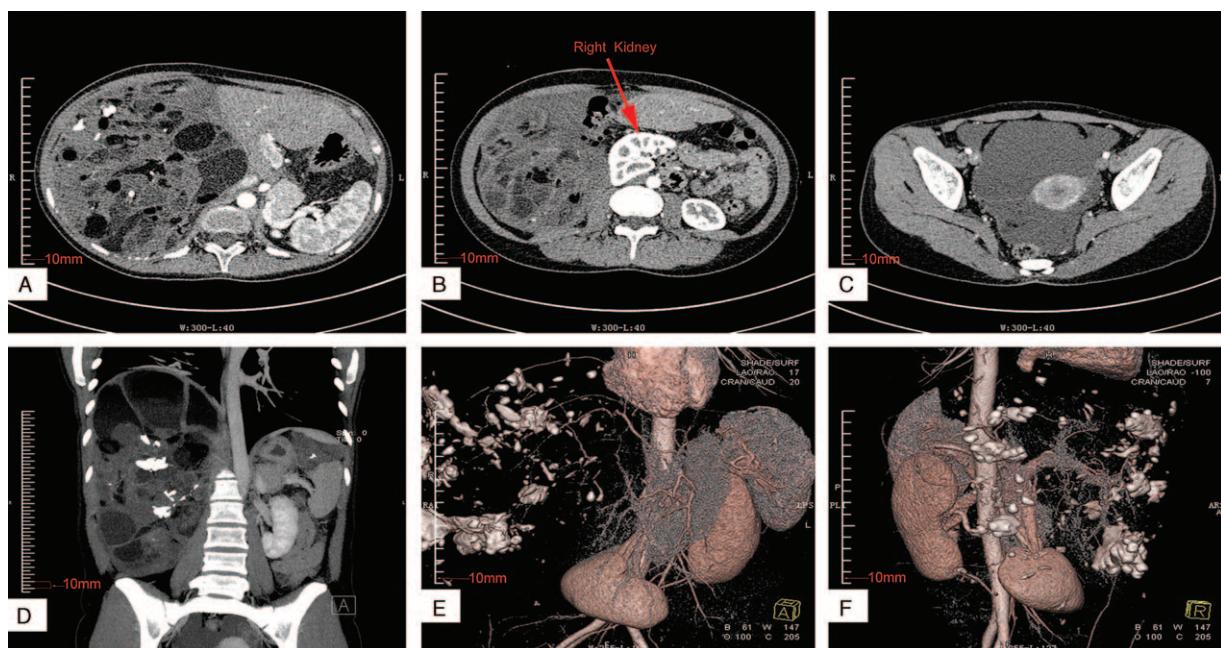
CT showed the mass occupying the right upper abdominal cavity, revealing multiple new masses containing cystic and necrotic elements surrounding the liver (A, D, E). Because of tumor compression, the giant mass had compressed the postcava, liver, pancreas, and the right kidney (B, C). The portal vein, right renal artery, superior mesenteric artery, and celiac trunk shifted to the left and was not invaded by the tumor through the technique of 3-dimensional CT image reconstruction (D, E, F). CT = computed tomography.
